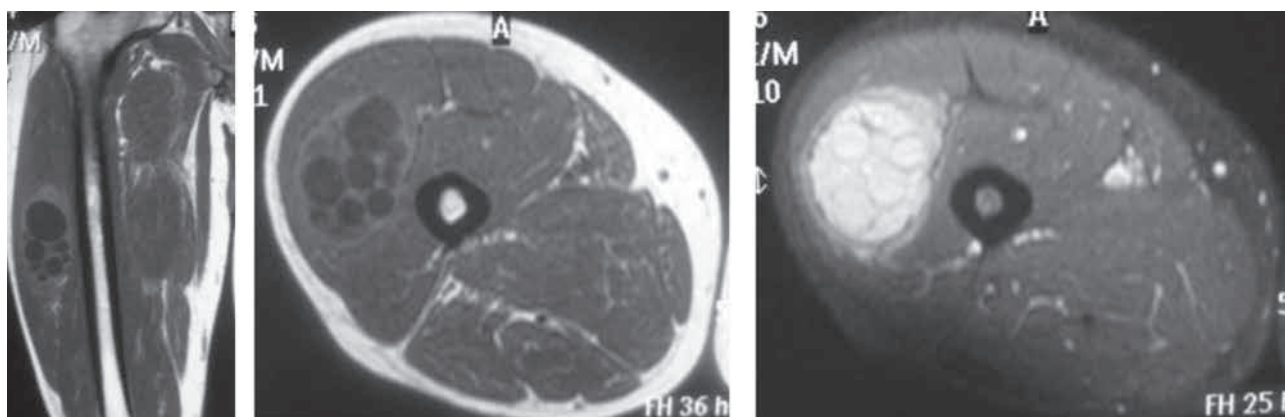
41-year-old male with muscle hydatidosis in the right vastus lateralis muscle. From left to right : coronal and axial T1-weighted images show an intramuscular well-defined soft tissue mass with multiple round hypointense nodules ; axial T2-weighted image demonstrates daughter cysts with higher signal intensity than the mother cyst.
